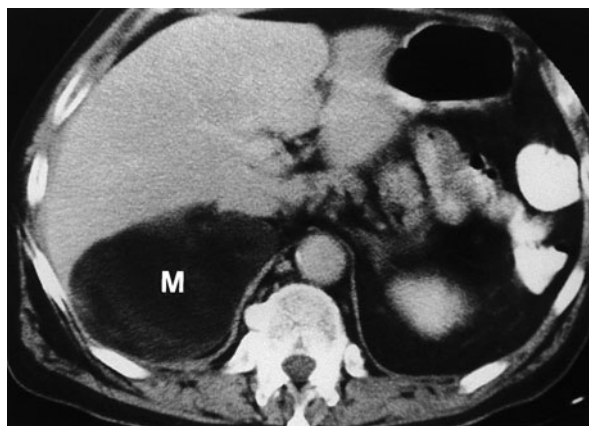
Myelolipoma. Large, fatty right adrenal mass (M) is seen on this contrast-enhanced computed tomography (CT) examination. (Reprinted with permission from [26])
